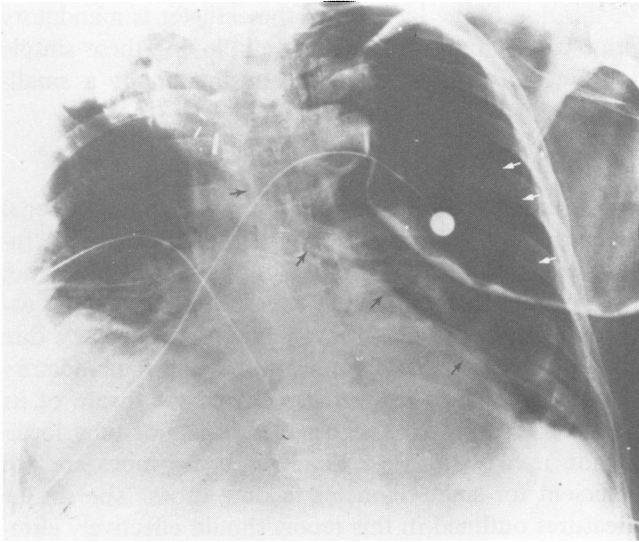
Chest x-ray reveals left-sided pneumothorax (white arrows). The feeding tube can be seen passing down the left mainstem bronchus into the left pleural space (black arrows).
